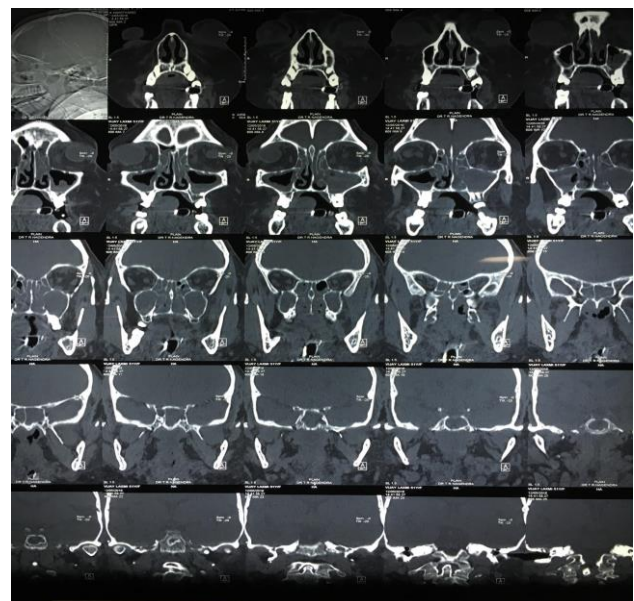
CT PNS mucosal thickening in bilateral maxillary sinuses.
